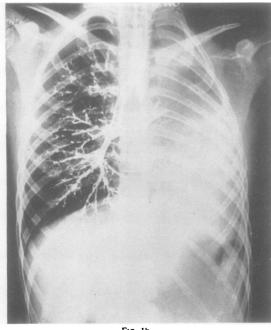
(a) Plain chest x-ray. The translucency in the left upper chest has been shown to be a mediastinal hernia containing the middle lobe. (b) Bronchogram.
